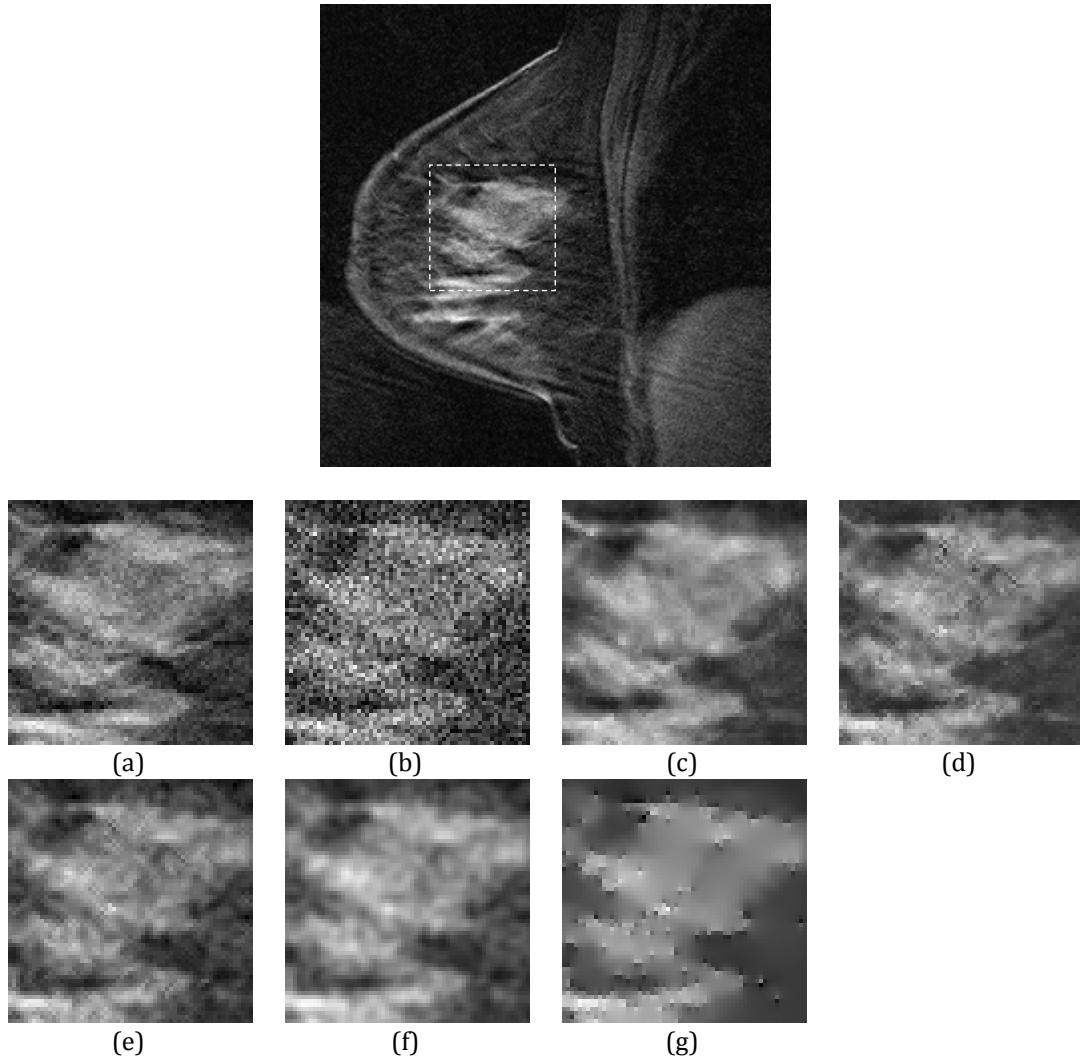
Clinical breast DCE-MRI image used in experiment 3. The denoising results are demonstrated on a selected patch of the image.
